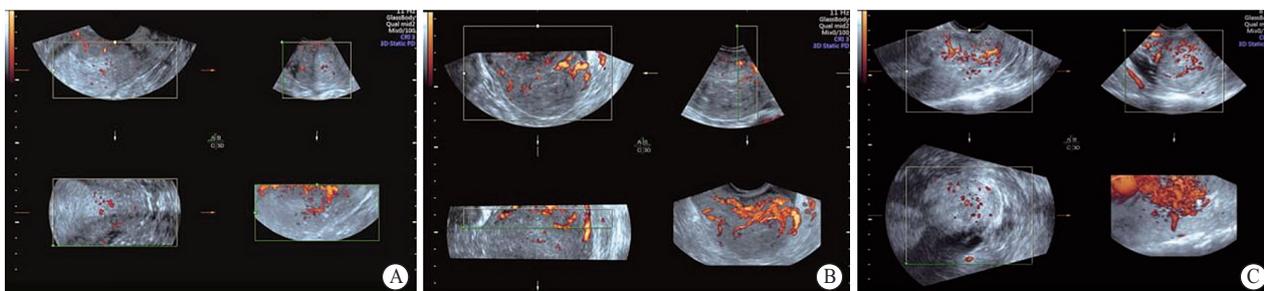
Images of endometrial polyps (A), submucosal myomas (B), and endometrial cancer (C) using three-dimensional power Doppler ultrasonography
